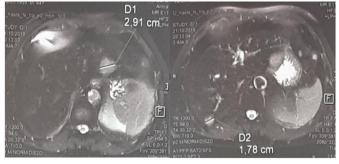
hepatic MRI showing metastases to the liver
